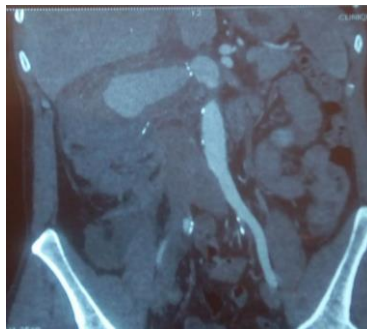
Frontal CT-scan view of a saccular aneurysm of the right renal artery with an important retroperitonéal hématoma raising up the liver and a poorly perfused right kidney
